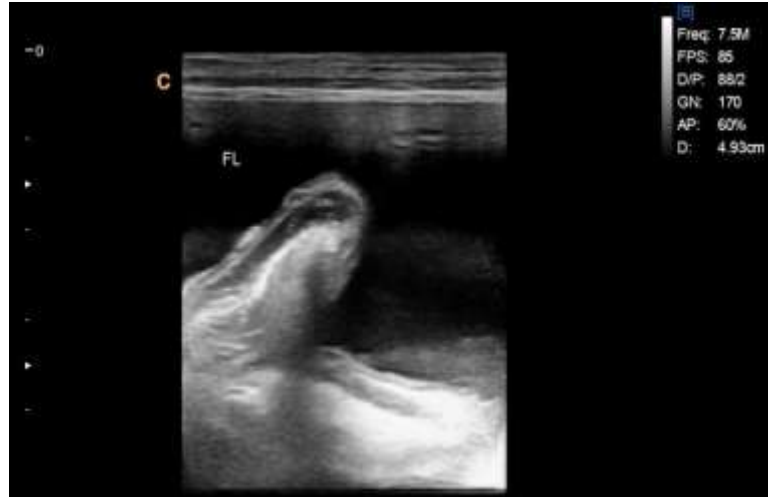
Sonogram depicting presence of anechoic fluid in the intraperitoneal space.
